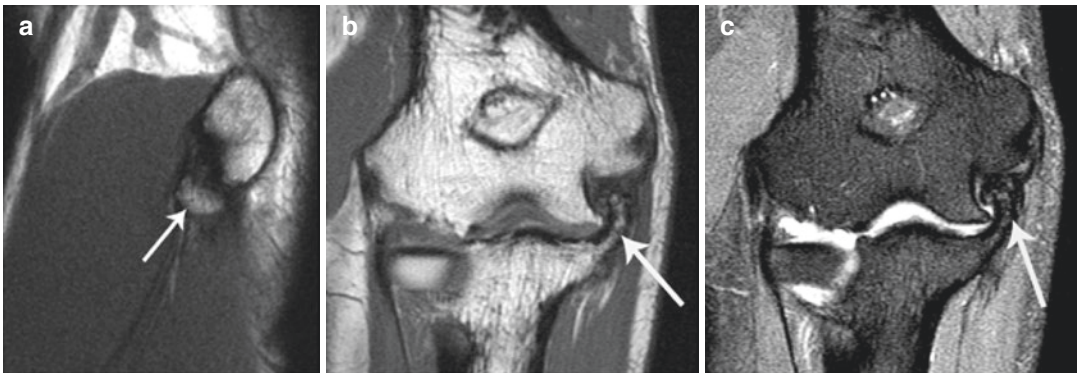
Sagittal image demonstrates a single ossicle (*arrow*) in the anterior band of the UCL (a). Coronal T1-weighted (b) and coronal IR (c) images demonstrate
